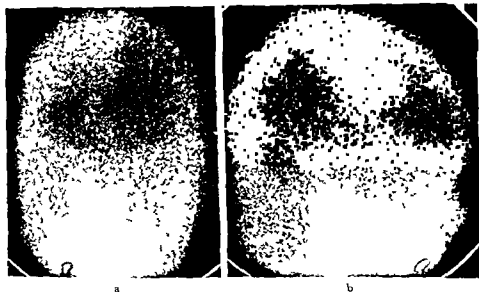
Ap (a) and right lateral (b) scintigrams. Arteriovenous malformation in right hemisphere
